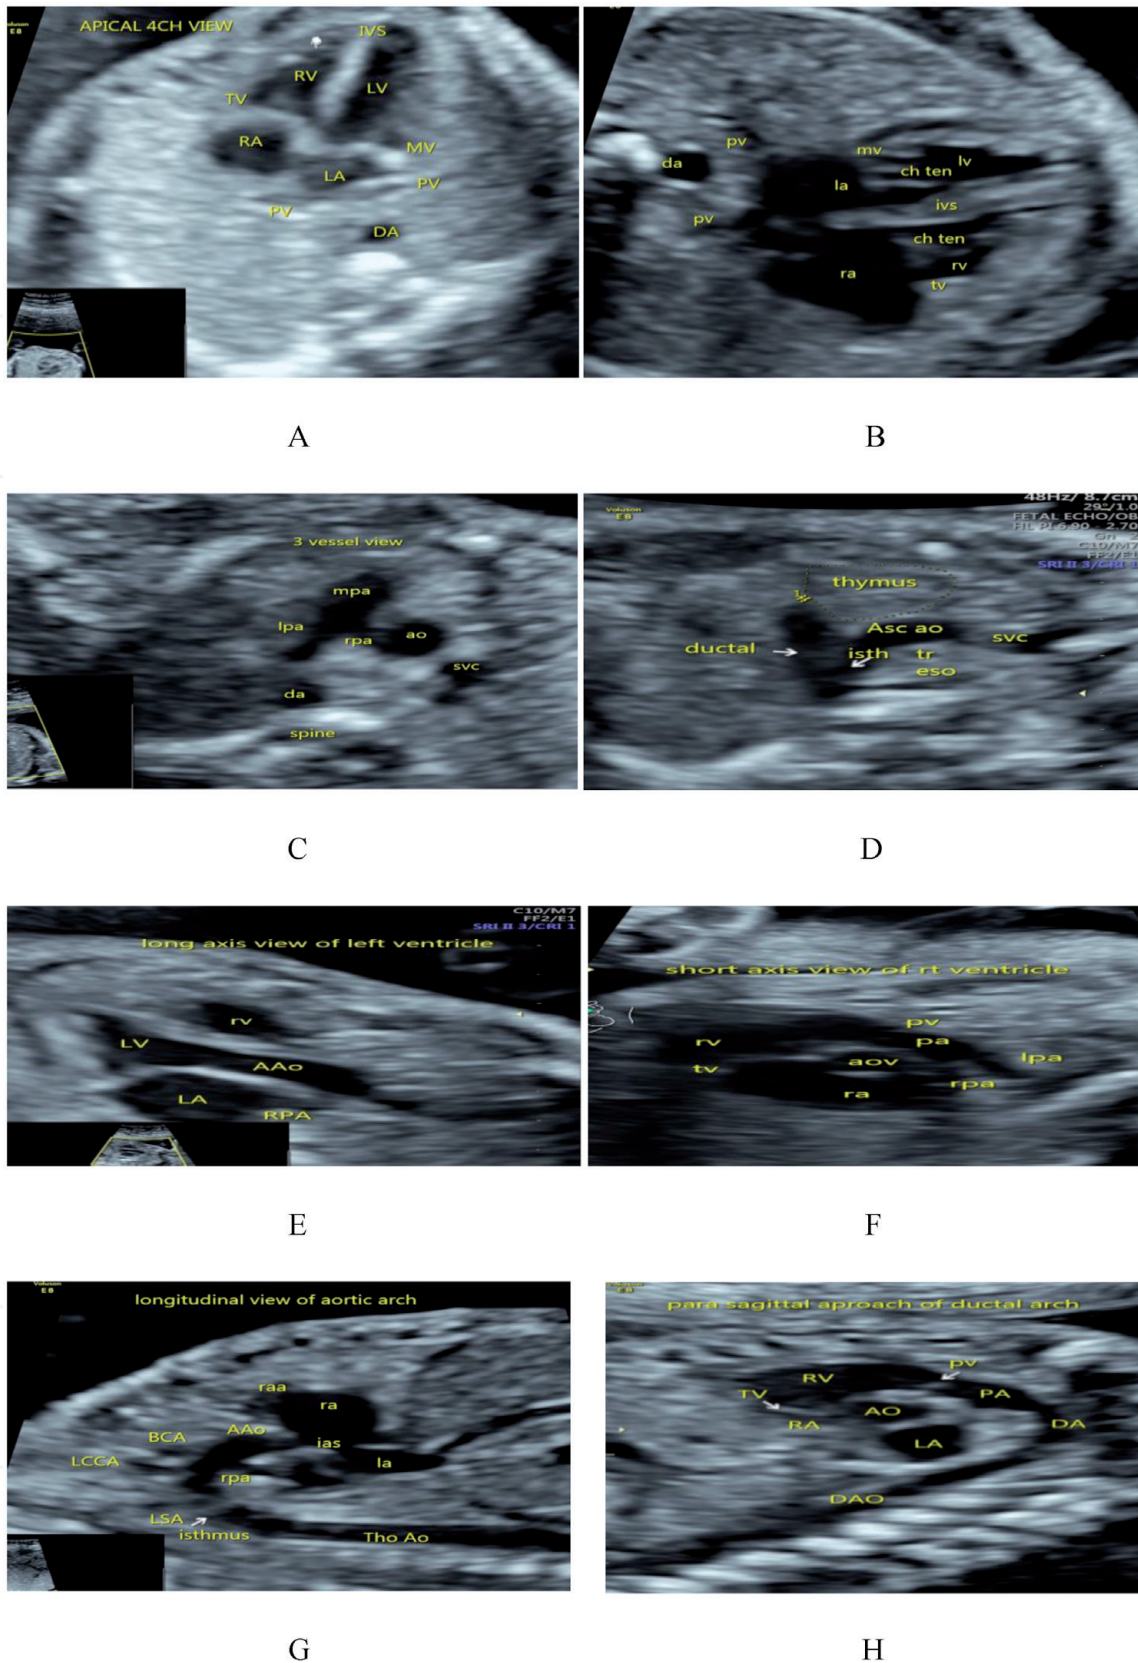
(A) Apical 4ch view. (B) Lateral 4 ch view. (C) 3vv. (D) 3VT. (E) Long axis view of left ventricle. (F) Short axis view of right ventricle. (G) Longitudinal view of aortic arch. (H) Parasagittal approach of ductal arch.
